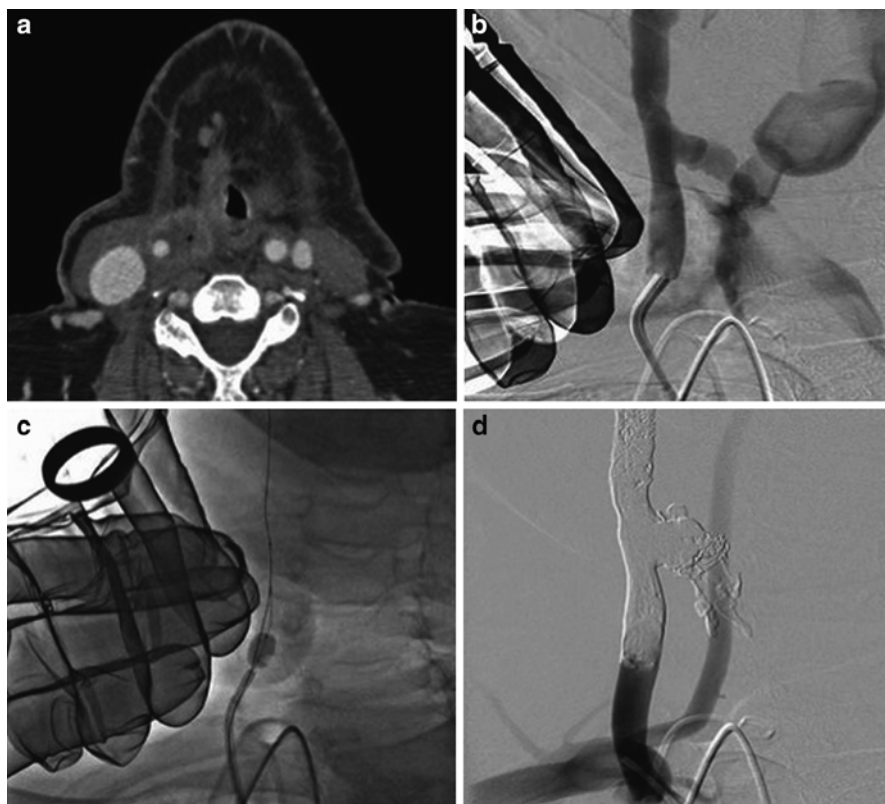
Carotid blowout. (a) Contrast cervical axial CT scan showing recurrent laryngeal cancer encasing the right carotid artery (*arrow*). (b) Pretreatment angiogram showing a carotid-esophageal fistula with manual compression being applied. (c) Inflation of a balloon in the common carotid artery proximal to the fistula to slow flow and reduce blood loss. (d) Carotid occlusion with coil deployment distal, within the fistula, and proximal to the fistula with EVOH deposition to complete the occlusion
